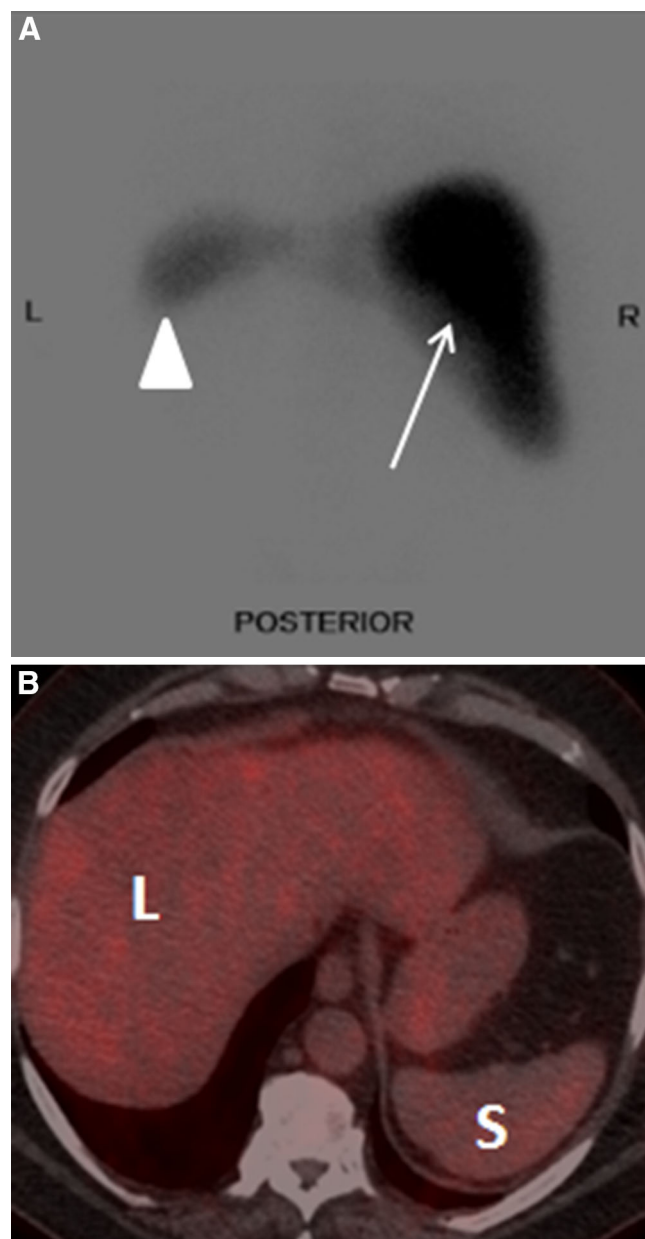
Normal spleen on nuclear imaging. A Sulfur colloid scan. Normal liver-spleen nuclear scan using Tc-99m sulfur colloid shows homogeneous radiotracer uptake in the spleen (*arrowhead*), while the liver has more avid uptake (*arrow*). B ^{18}F FDG (PET-CT). Axial image showing homogeneous uptake in the spleen (S) above normal blood pool but less than that of the liver (L).
